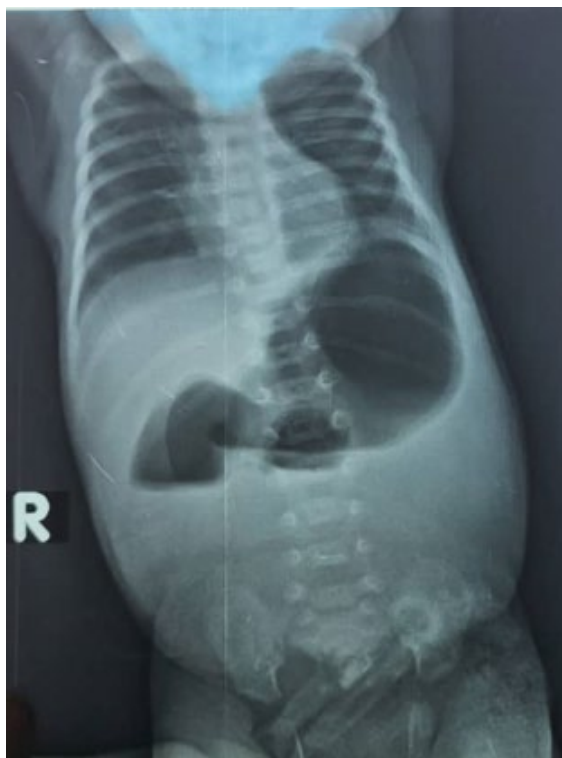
Abdominal radiograph showing a “double-bubble” sign.
